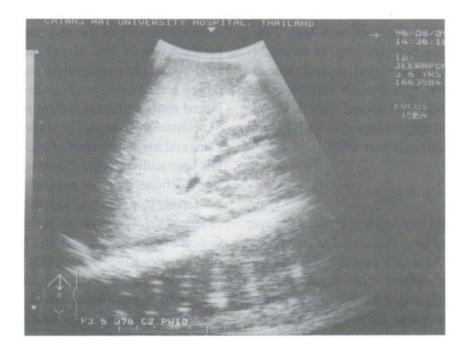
Longitudinal sonogram of mid upper abdomen shows enlarged liver and multiple enlarged mesenteric and retroperitoneal lymph nodes.
